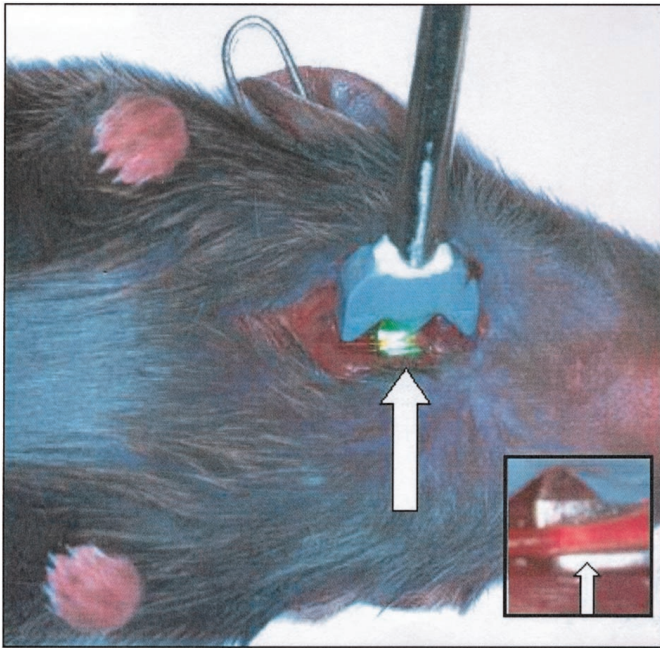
Carotid photochemical injury model. Doppler flow probe monitoring blood flow in right carotid artery, which is being exposed to green light (large arrow). Right lower inset shows gross appearance of clot within carotid artery (small arrow), at which time no flow is apparent by Doppler.
